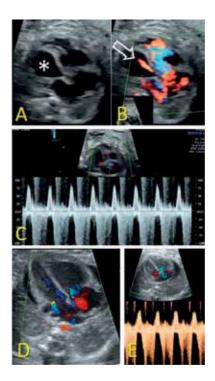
Applications of color and spectral Doppler. (A): Critical aortic stenosis with dysplastic left ventricle (*), atretic valve and aortic regurgitation (arrow, (B)). (C): Same case, tricuspid regurgitation, pulsed Doppler evaluation. (D): Atrioventricular valves regurgitation associated with cardiomegaly. (E): Same case, spectral Doppler evaluation of atrioventricular flow.
